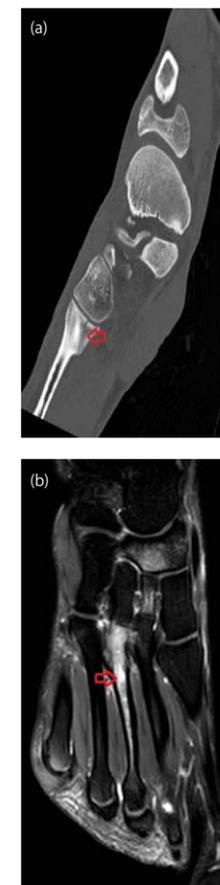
23-year-old patient, 2nd Handball Bundesliga with proximal fracture of the third metatarsal: (a) CT shows proximal fracture of the third metatarsal with joint involvement; (b) also evidence of bone marrow oedema throughout the third metatarsal on MRI.
